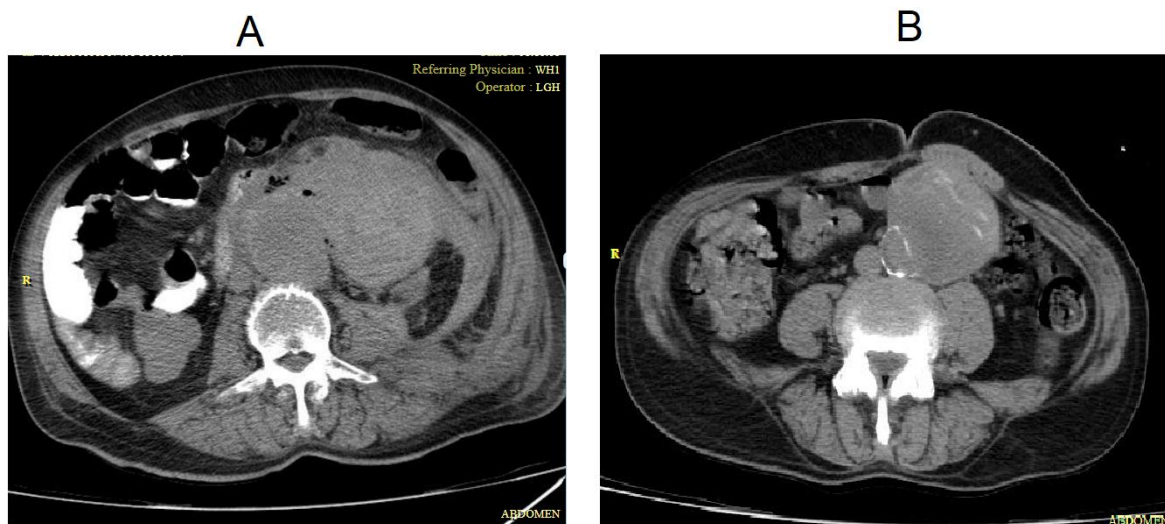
CT Angiography, A; patient 1, B; patient 2.
